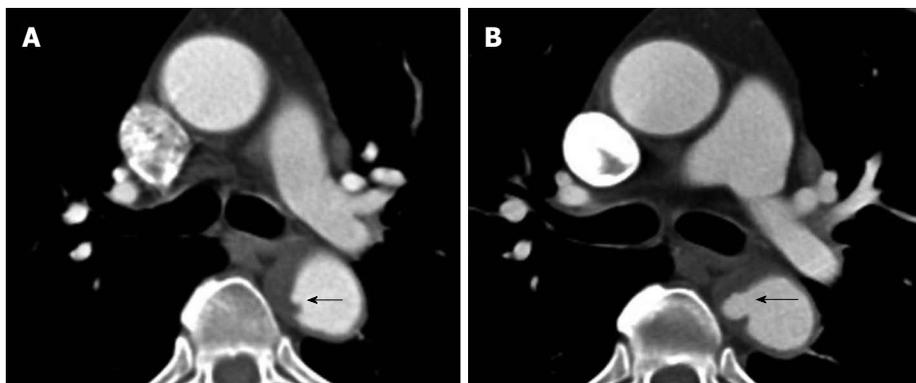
Computed tomography aortogram in a 75-year-old man shows an intramural hematoma (note the eccentric wall thickening in the descending aorta) with intimal surface defect (A: arrow). At one year follow up it has progressed into a frank penetrating ulcer (B: arrow).
